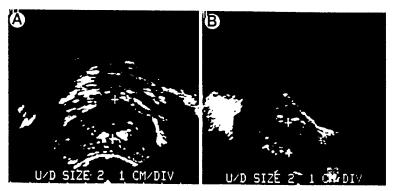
Transrectal ultrasound, A, height of transition zone in transverse view (2.0 cm.), B, "salami effect" height of transition zone in longitudinal view (1.6 cm.)
